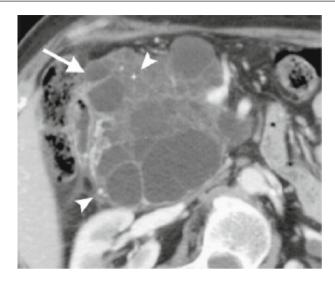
CT scan findings of a patient with mucinous cystic neoplasm. Multiple cystic spaces with variable thickness septations are apparent (arrow) and generally considered a risk of malignancy. Peripheral calcifications (arrowheads) within the septa are noted in up to 15% of patients.
